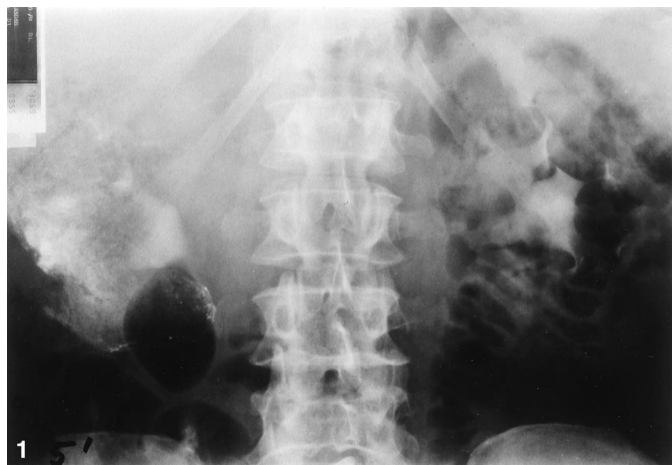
Abdominal radiograph (case 2) reveals an atypical configuration localized in the right hypochondrium.
